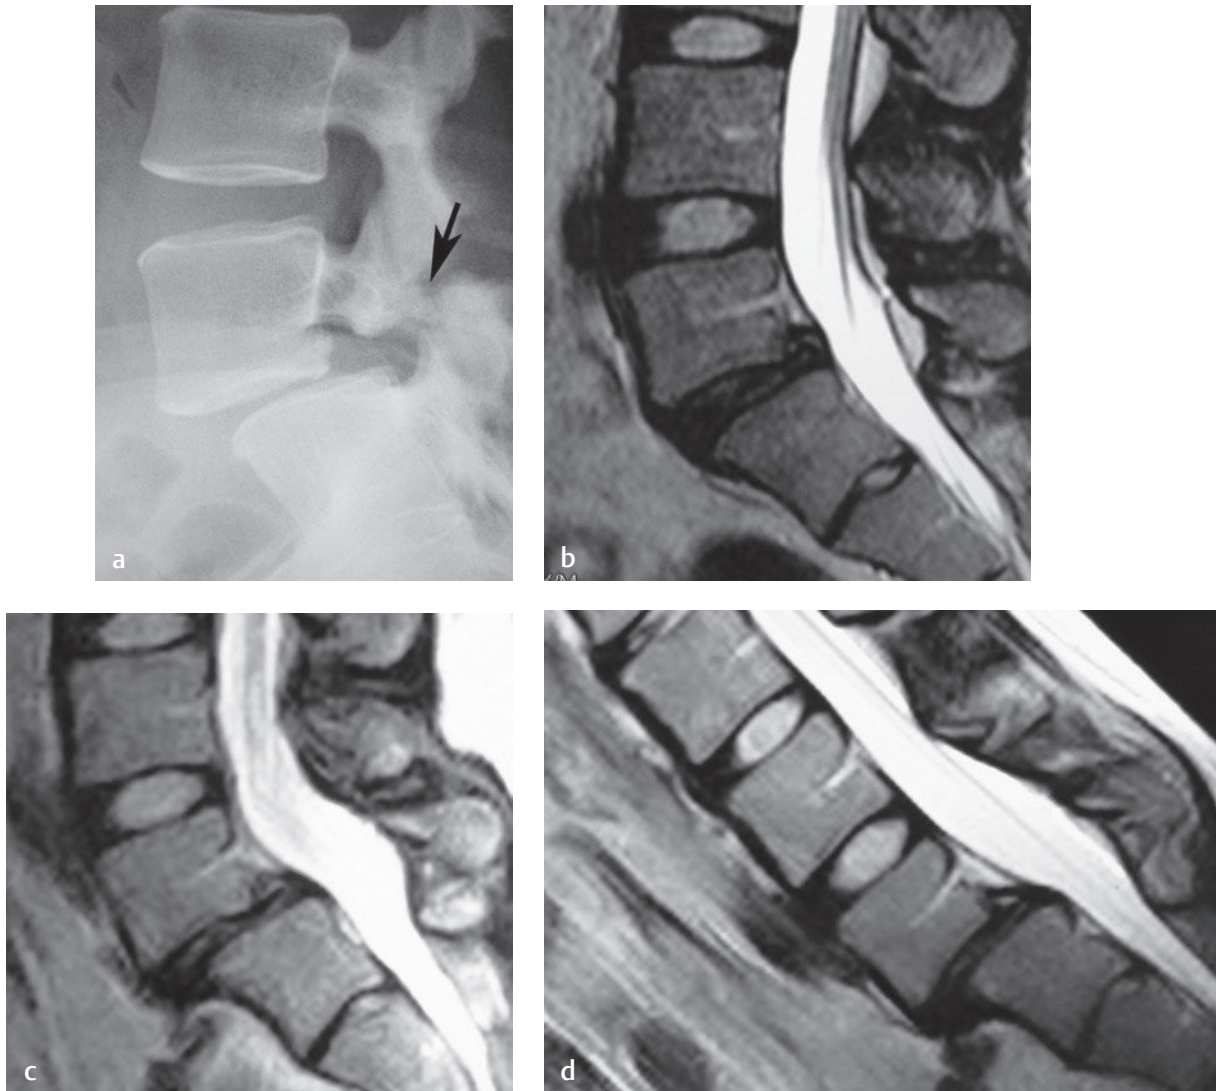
Isthmic spondylolisthesis. (a) A lateral radiograph shows bilateral pars intraarticularis defects (*arrow*) at the L5-S1 level with Meyerding grade-2 spondylolisthesis. (b) A sagittal T2-weighted MR image obtained via a closed system with the same patient in a supine position shows grade-1 spondylolisthesis. (c) A sagittal T2-weighted MR image obtained via an open MRI system with the patient in a standing position shows that the spondylolisthesis progresses to grade 2. (d) A sagittal T2-weighted image obtained via an open MRI system with the patient in a flexed position shows that the grade-2 spondylolisthesis progresses compared with images in the (c) neutral and (b) supine positions.[†]
